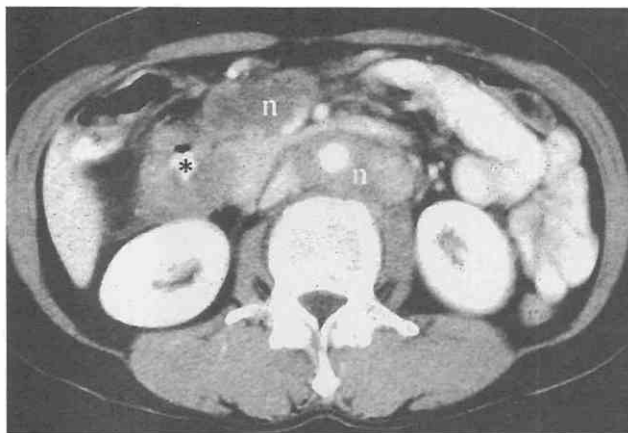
Ascending colon cancer (not shown) with duodenal invasion. CT scan shows heterogeneous duodenal wall thickening (asterisk) along with lymphadenopathy (n) in the retroperitoneum and peripancreatic region.
